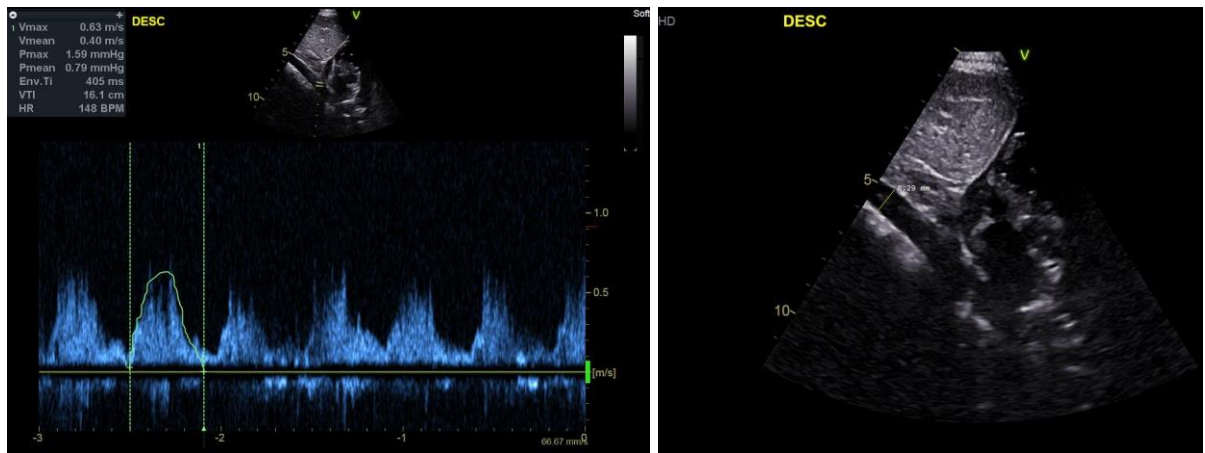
Descending aorta echocardiography results from a pre-intervention investigation only as a post-intervention measurement was not possible.
